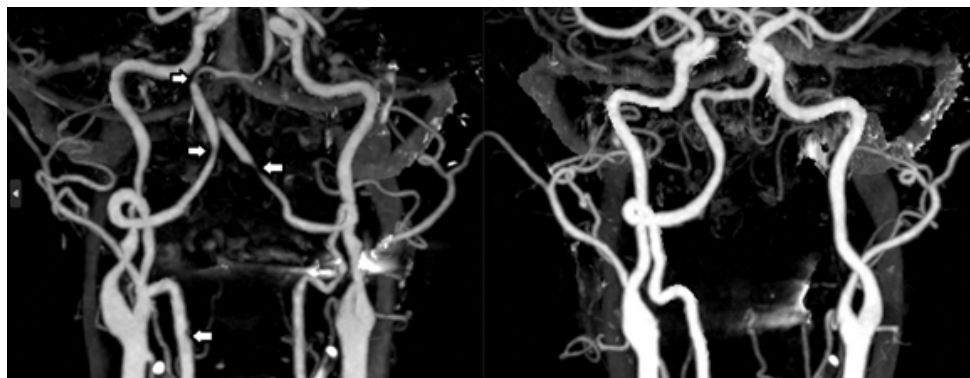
(A) Computed tomography of circle of Willis showing multifocal narrowing (white arrows) on presentation and (B) at 2 months.
